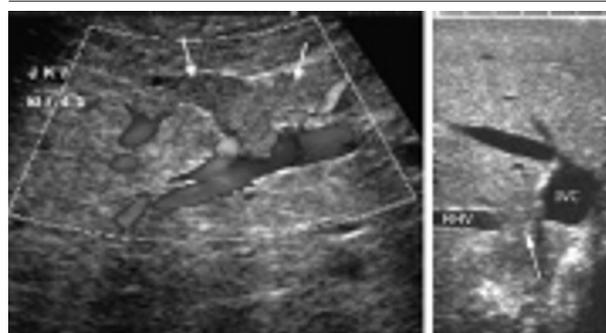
(6) Thrombus. Intraoperative color Doppler flow image obtained during US-guided metastasectomy in a patient with hepatocellular carcinoma shows a thrombus in the left portal vein (arrows). (7) Vascular invasion by metastasis. Intraoperative US image demonstrates a colorectal cancer metastasis (arrow) that has invaded the distal portion of the right hepatic vein (RHV) at its confluence with the adjacent vena cava (IVC). In this setting if resection is performed, segment VII (posterior to the right hepatic vein) and segment VIII (posterior to the right hepatic vein) of the liver are likely to be resected.
